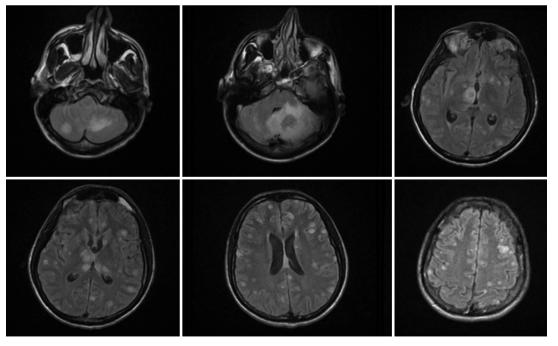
FLAIR-weighted images of patient 3 with cerebral toxoplasmosis *FLAIR: Fluid-attenuated inversion recovery*
